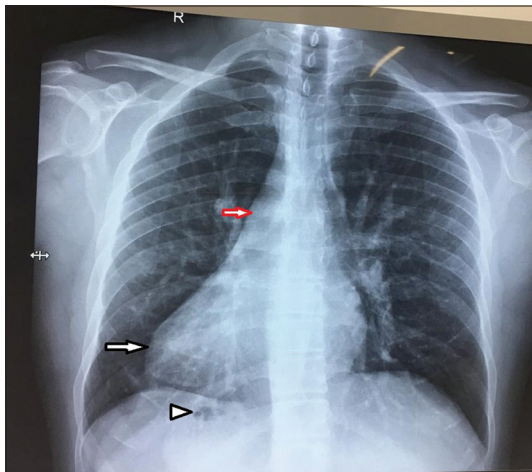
Chest radiograph showing dextrocardia (black arrow), right aortic arch (red arrow), and gastric bubble on the right side (arrow head).
